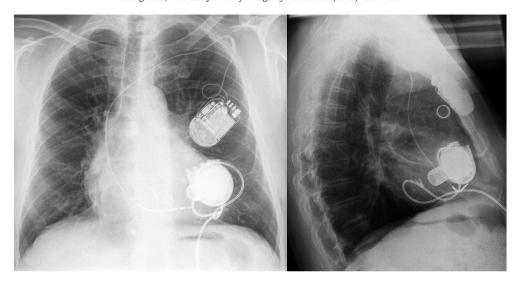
Chest radiograph of LVAD with ICD. From https://commons.wikimedia.org/wiki/File:Left_ventricular_assist_device_-_56jm_-_Roe_-_001.jpg
